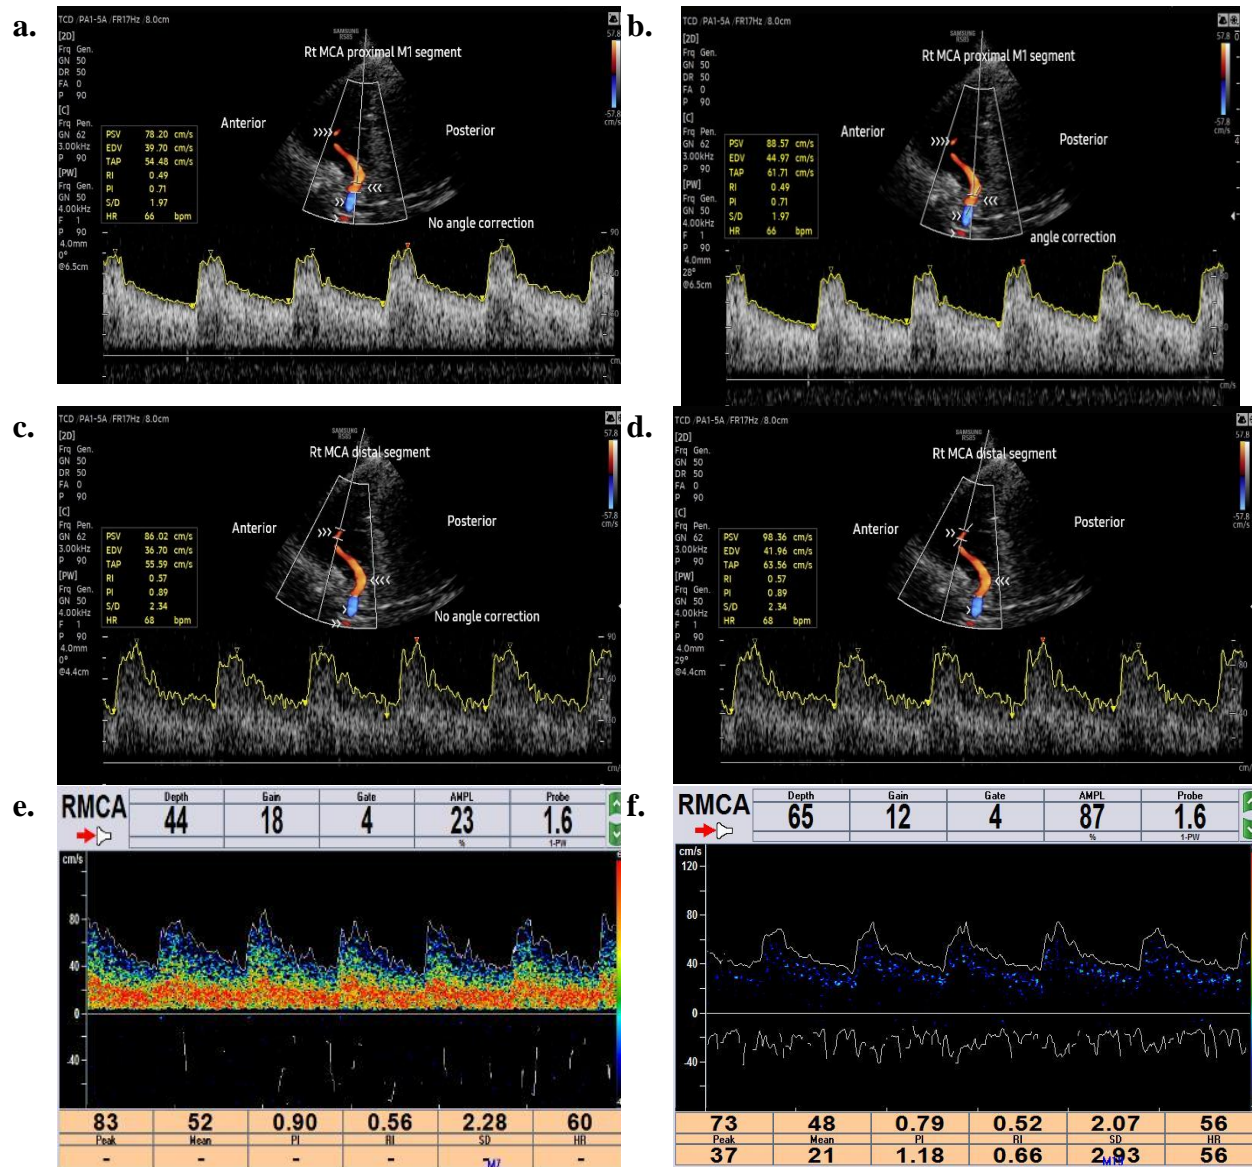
Images of a 40 year old healthy subject showing the ROIs and the Doppler signal acquisition techniques: (A.) ncTCCD measurement of PSV and TAP of proximal MCA (triple arrowheads), (B.) cTCCD measurement of PSV and TAP of proximal MCA (triple arrowheads), (C.) ncTCCD measurement of PSV and TAP of distal MCA (triple arrowheads), and (D.) cTCCD measurement of PSV and TAP of distal MCA (double arrowheads). (E.) TCD waveform showing measurement of PSV and MFV at distal depth of MCA, (F.) TCD waveform showing measurement of PSV and MFV at proximal depth of MCA. The long vessel color-coded in red is the right MCA whereas the ipsilateral anterior cerebral artery segment is color-coded in blue.
